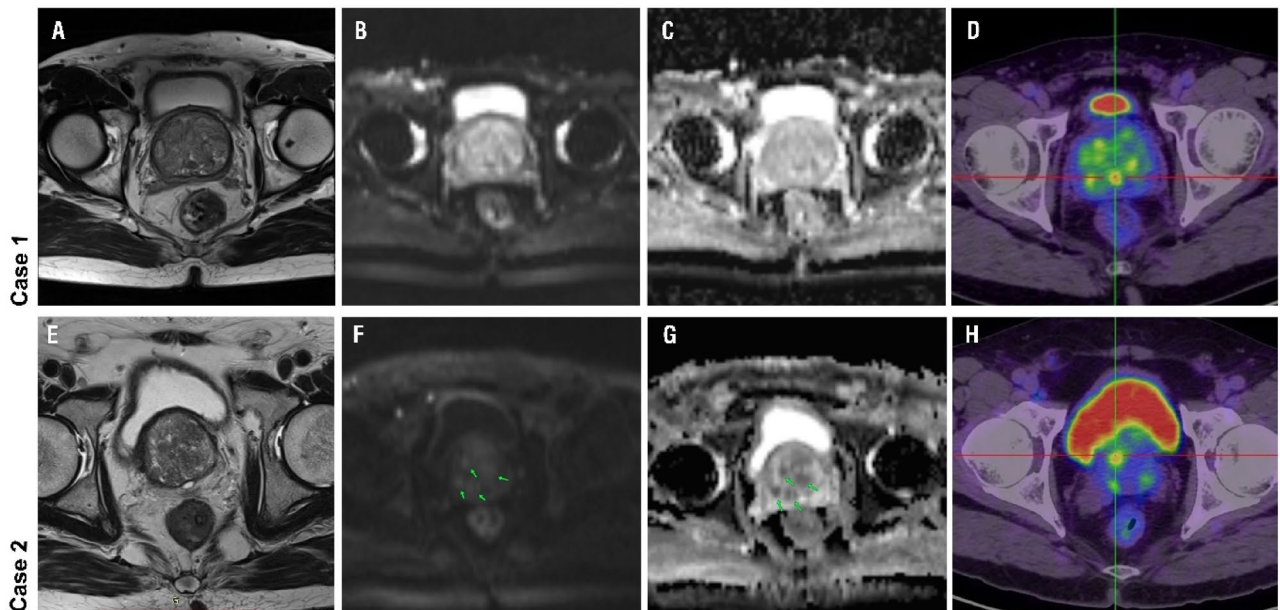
Correction of misdiagnoses by PSP Model. Case 1. A 72-year-old man with PI-RADS score 2, SUVmax 10.5, PSA 8.4ng/ml, and PSAD 0.40ng/ml/cm³. (A) T2 showed homogeneous hyperplasia of the central and transition zones of the prostate; (B) DWI showed no significant diffusion restriction; (C) ADC signal was not reduced; (D) 68Ga-PSMA PET/CT showed a less obvious focal PSMA activity lesion (crosshair). The PSP Model indicated high risks (33.6% csPCa probability); biopsy pathology was ISUP 2 (Gleason 3+4). Case 2. A 69-year-old man with PI-RADS score 2, SUVmax 10.8, PSA 7.2ng/ml, and PSAD 0.18ng/ml/cm³. (E) T2 showed several well-circumscribed prostate nodules; (F-G) DWI showed slightly diffusion restriction, ADC signal was slightly reduced (green arrow); (H) 68Ga-PSMA PET/CT showed a less obvious focal PSMA activity lesion (crosshair). The PSP Model indicated low risks (27.0% csPCa probability); biopsy pathology were benign prostatic nodules. This figure is only an example case and is not directly representative of the overall statistical performance of the model.
